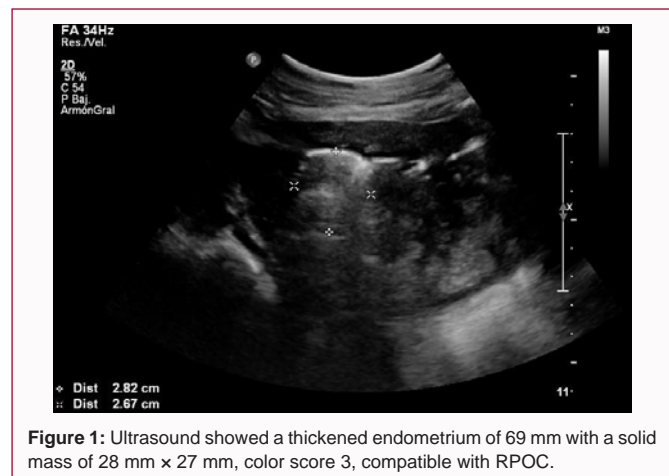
Ultrasound showed a thickened endometrium of 69 mm with a solid mass of 28 mm × 27 mm, color score 3, compatible with RPOC.
